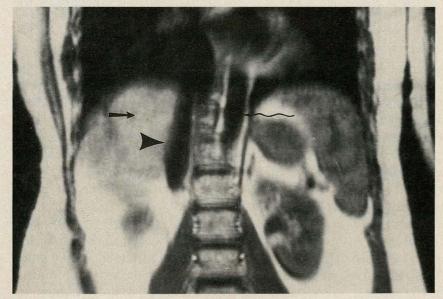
Coronal T1-weighted image through lower portion of chest and upper part of abdomen. Lungs appear dark because air does not produce a signal. Arrow indicates liver. Abdominal vessels (arrowhead, inferior vena cava; wavy arrow, aorta) are well visualized secondary to signal void phenomenon.
